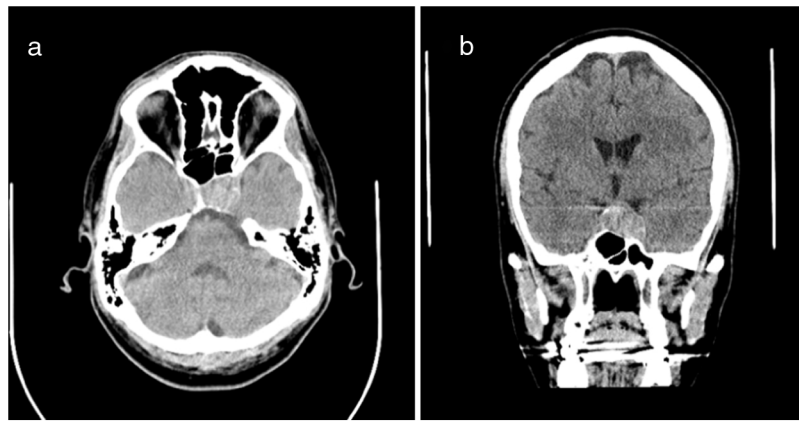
(a and b) Computed tomography without contrast. Axial (a) and coronal (b) slices show predominantly hyperdense sellar mass measuring $1.9 \times 2.8 \times 2.0$ cm eccentric to the left with extension into the suprasellar cistern, impingement on the left optic chiasm, and dehiscence of the bilateral posterior sphenoid sinus walls.
